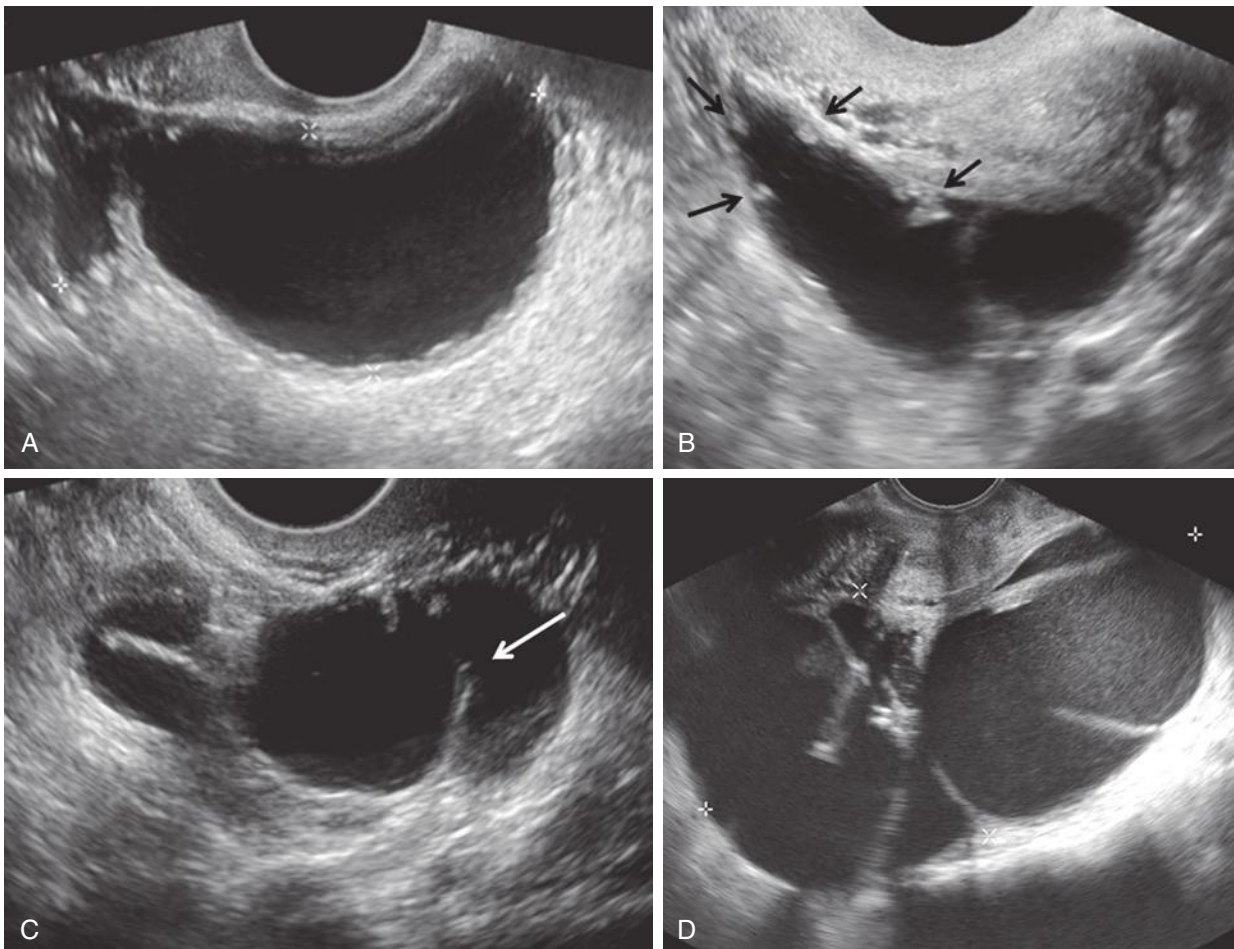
Sonographic spectrum of hydrosalpinx. A, Dilated fallopian tube appears as an anechoic fluid-filled, avascular tubular structure (*calipers*). B, The endosalpingeal folds (*arrows*) appear as beads on a string. C, Incomplete septation (*arrow*) is formed by the tube folding upon itself. D, Pitfall: mucinous cystadenoma (*calipers*) appears tubular in configuration with incomplete septations and mimics a distended fallopian tube.
